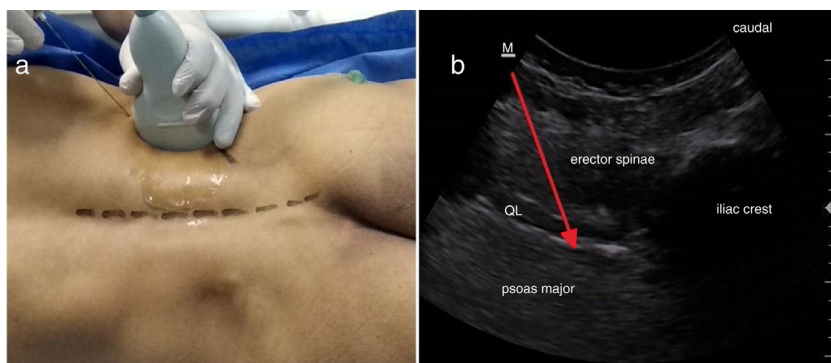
(a) Probe position and needle direction, (b) Characteristic sonographic image of triple muscle layers from posterior to anterior: Erector spinae, Quadratus Lumborum (QL), and Psoas Major (PM) muscles, respectively. Anterior thoraco-lumbar fascia is seen separating QL and PM muscles. Red arrow represents needle path to endpoint of injection.
